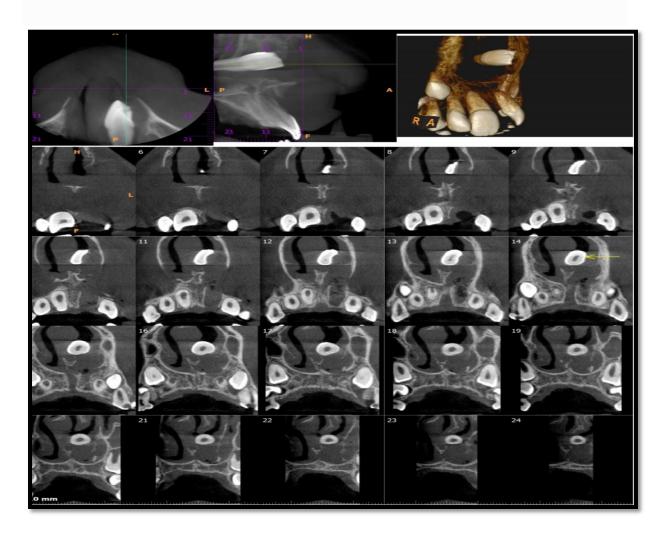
Axial CBCT. Hyperdensity image into the nasal cavity and thus confirmed the suspicion of a tooth into the nasal cavity.
